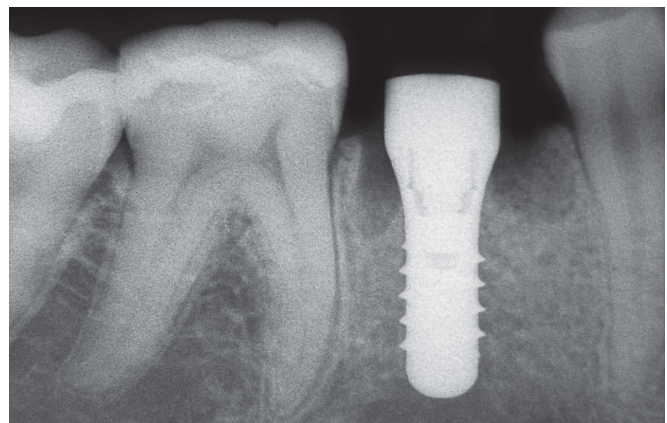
Postoperative radiograph shows implant installed immediately after extraction of deciduous teeth.
